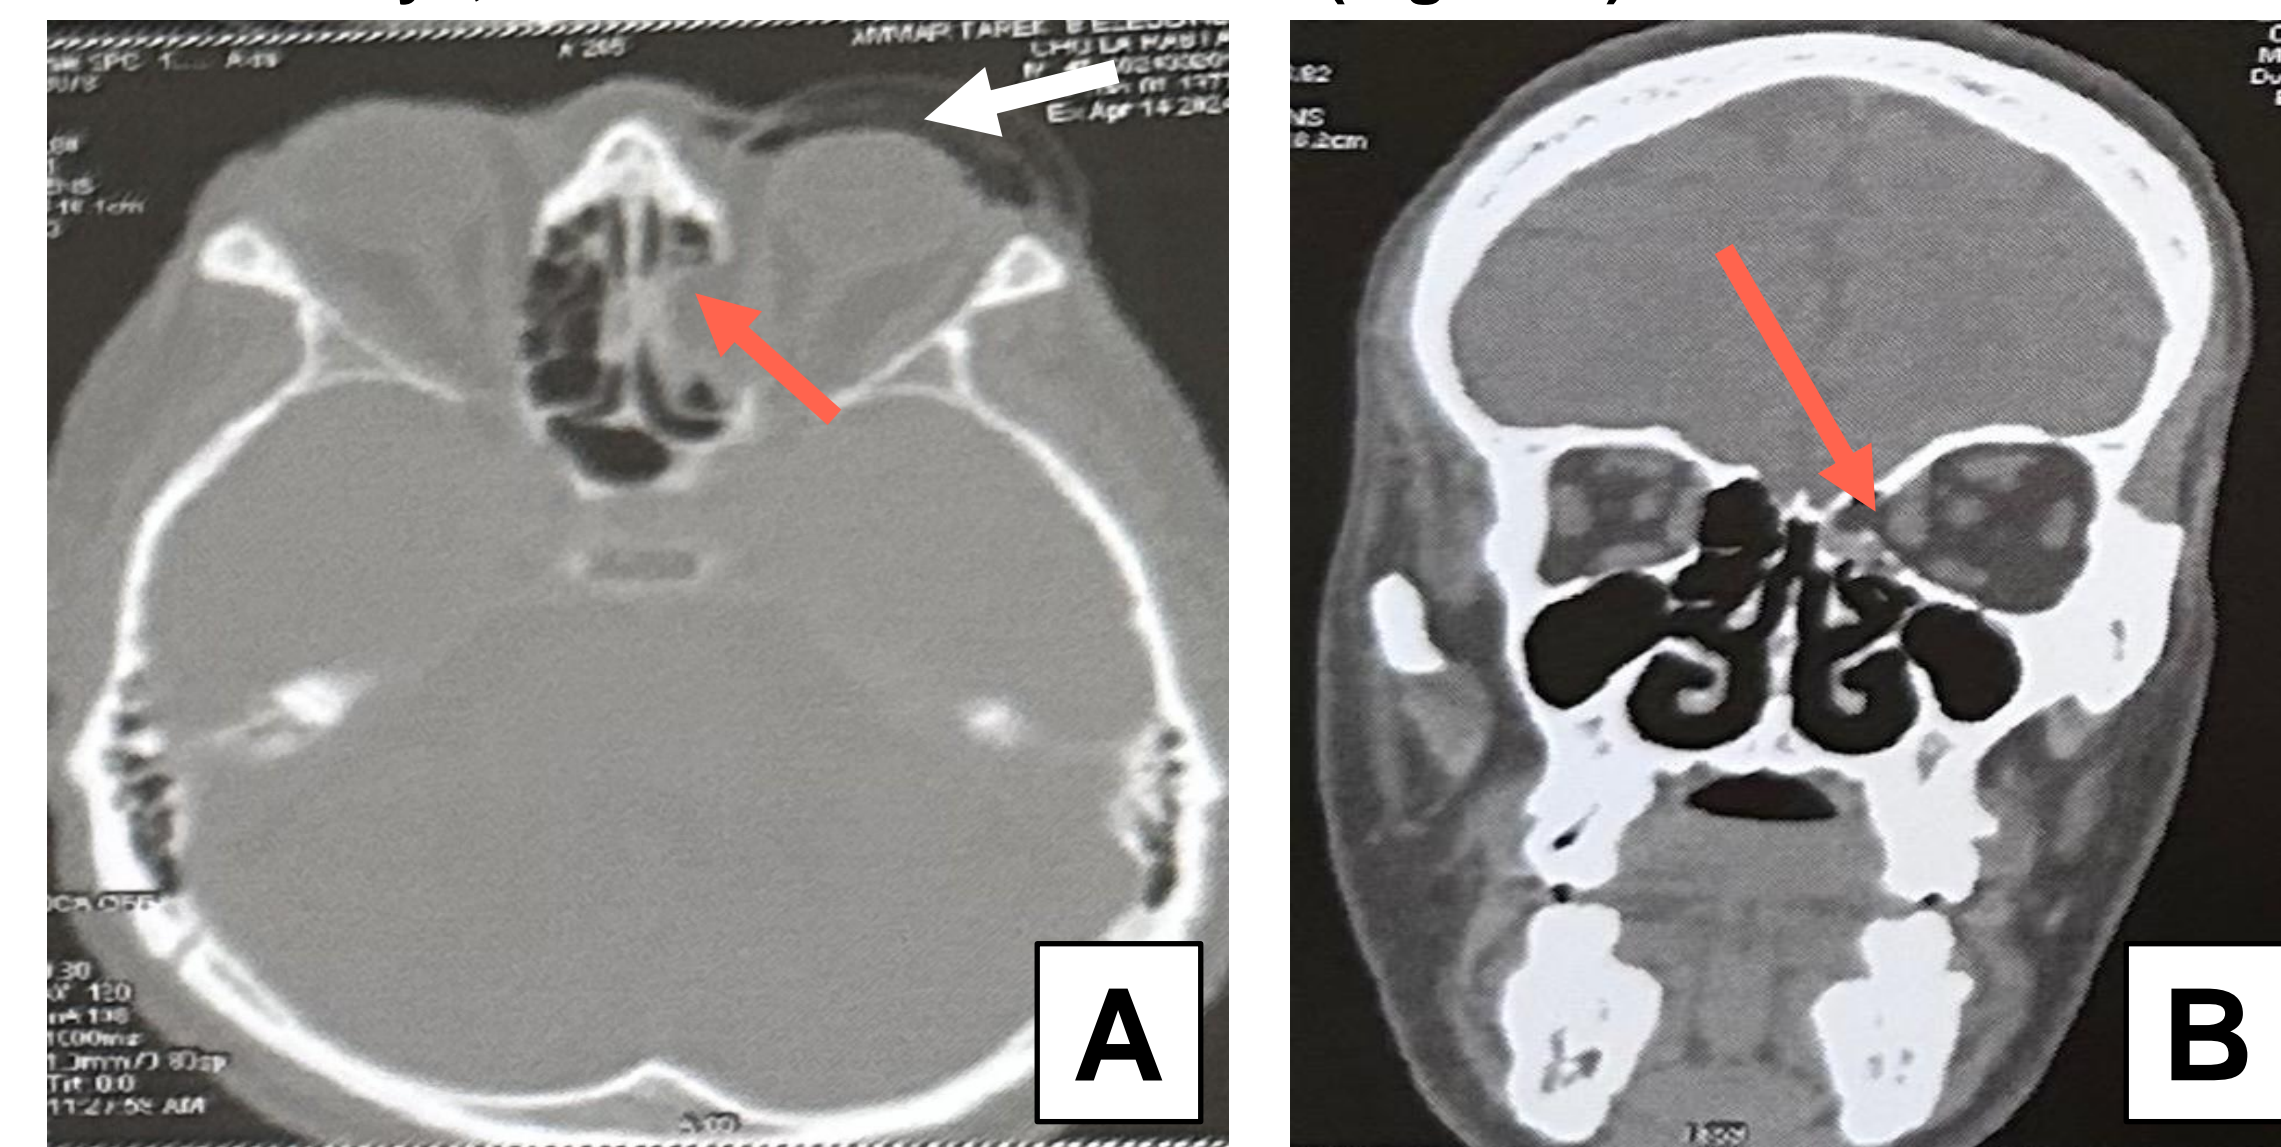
A: Axial CT scan showing a blow-out fracture is seen on the medial wall of left orbit (red arrow) with air inside the soft tissue areas (white arrow)
